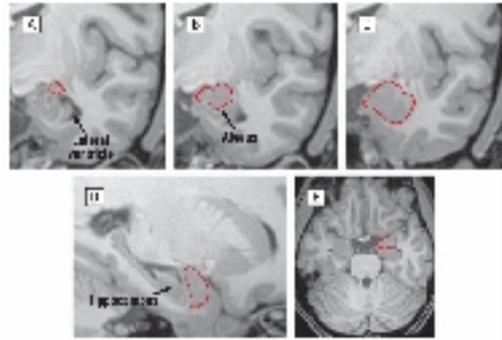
Amygdala was traced in high-resolution T1-weighted images by using the software MultiTracer.
